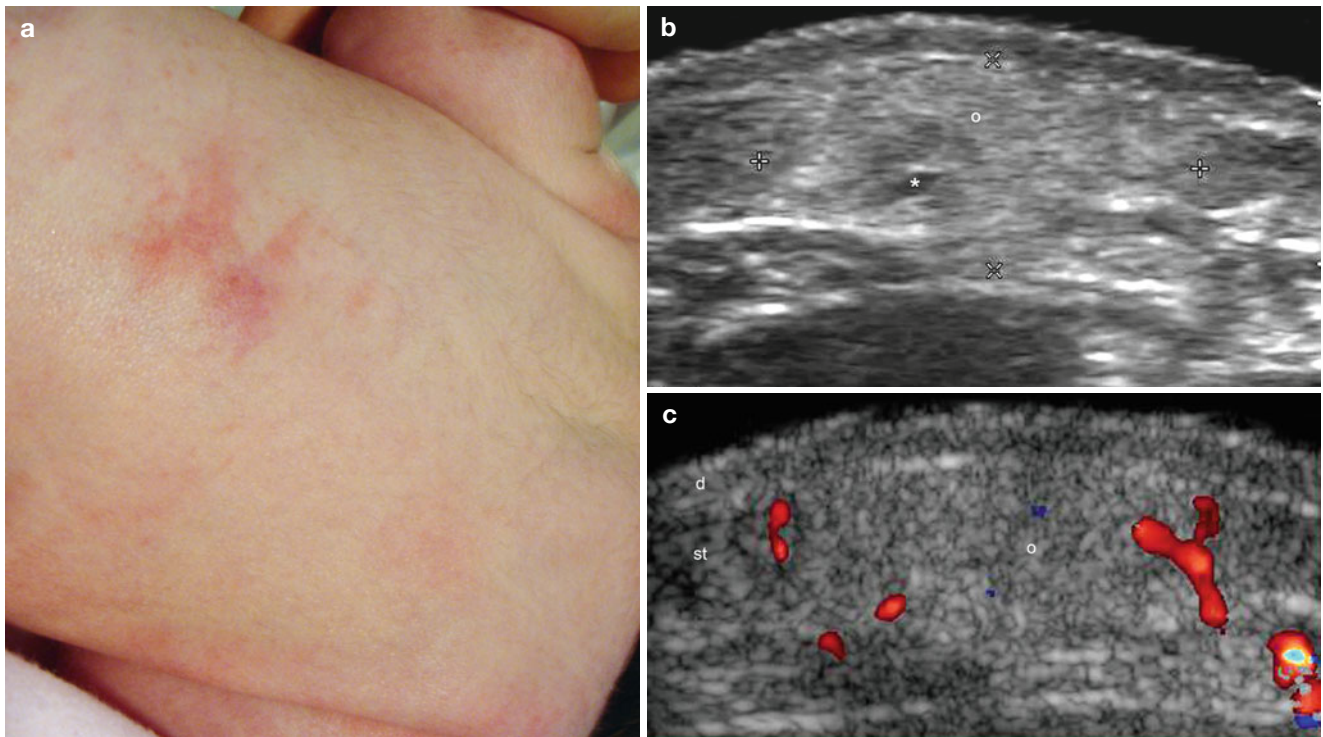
(a–c) Mostly lobular panniculitis. Fat Necrosis of the newborn. (a) Clinical image shows erythema and swelling in the dorsolumbar region in a newborn. (b) Gray scale ultrasound image (transverse view) demonstrates increased echogenicity of the fatty lobules of the subcutaneous tissue with blurriness of the borders of the lobules (o).
